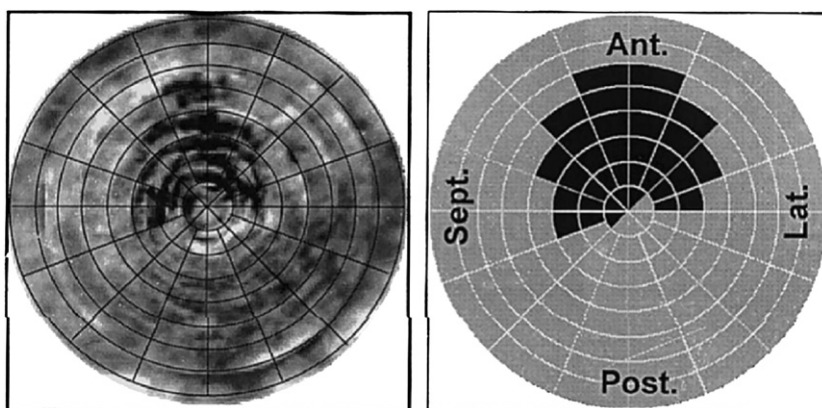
Bulls-eye image formed from a contrast-enhanced 3D data set (left) and the corresponding binary image showing underperfused sectors (right). (Reproduced from Yao J, De CS, Delabays A, et al. Bulls-eye display and quantitation of myocardial perfusion defects using 3D contrast echocardiography. *Echocardiography* 2001;18:581–8; with permission.)
